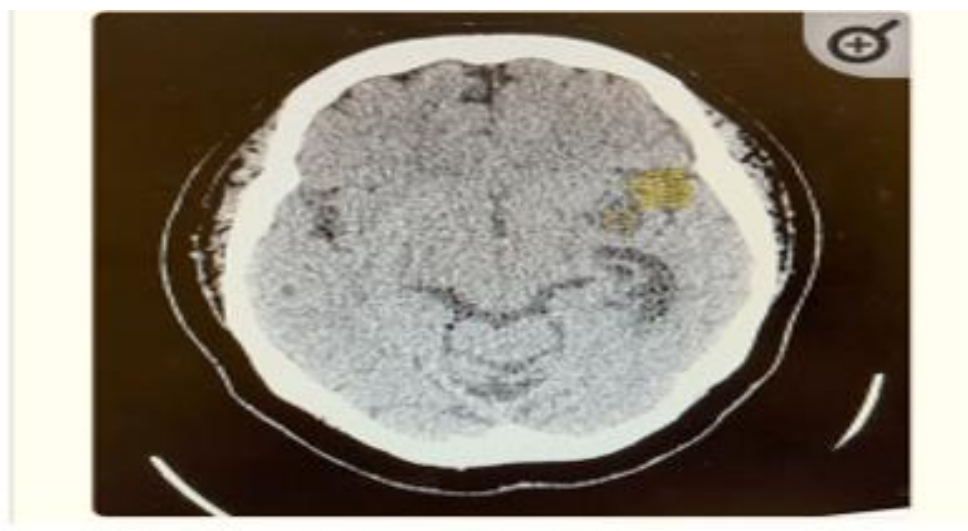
CT scan showing axonal view of lesion.
